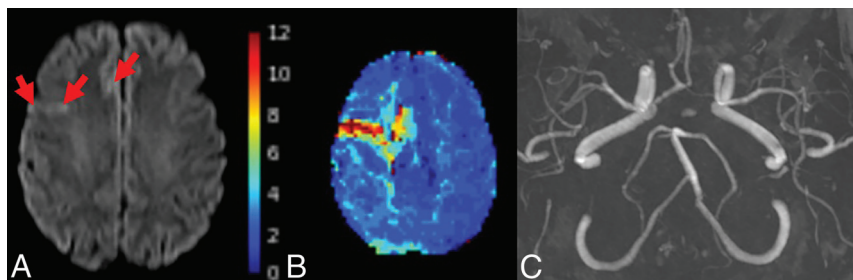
Acute fast Code Stroke MR imaging. A 51-year-old woman with new left-sided weakness, last seen well 12 hours earlier. Abbreviated MR imaging protocol with fast DWI, PWI, SWI, TOF-MRA, and T1 neck was performed. A, DWI shows small foci of cortical restricted diffusion in the right frontal lobe in the MCA and anterior cerebral artery territories. B, The Tmax map shows severe delay in the distribution of the right MCA M3 and anterior cerebral artery A4 branches. C, TOF-MRA MIP shows no large-vessel occlusion. An M3 occlusion is evident on source images.
